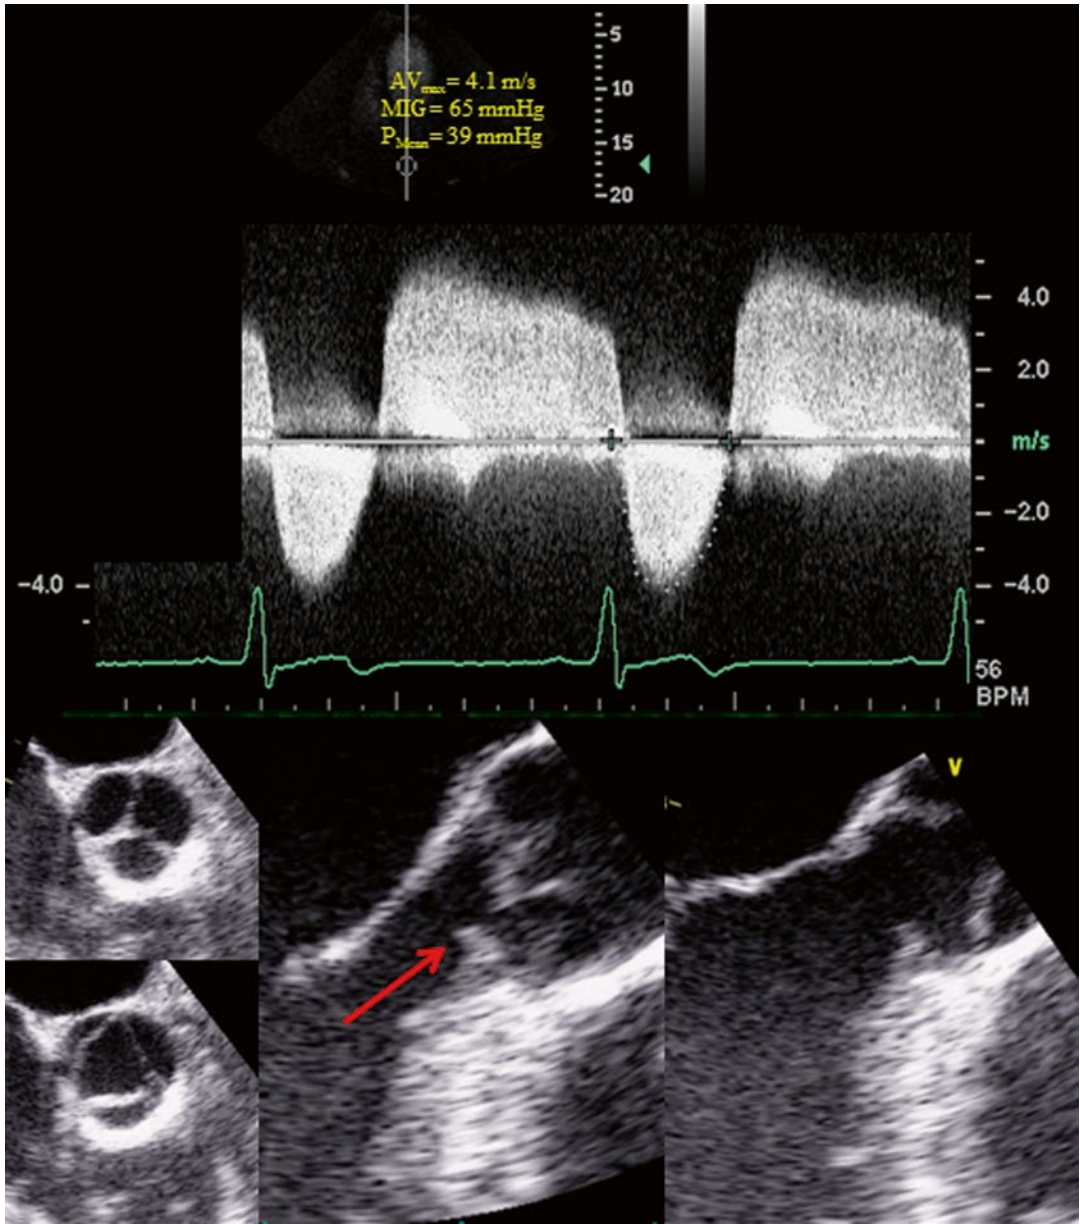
Case 6: Para-valvular obstruction. A Subaortic membrane: 26 year old, asymptomatic male presents for echocardiographic evaluation of a harsh, systolic murmur. Pressure gradients across the aortic valve are determined to be elevated despite a normal appearing valve. Echocardiographic Data (TTE), Top panel: ΔP_{mean} : 39 mmHg, ΔP_{MIG} : 67 mmHg. Severe AS by gradient is
